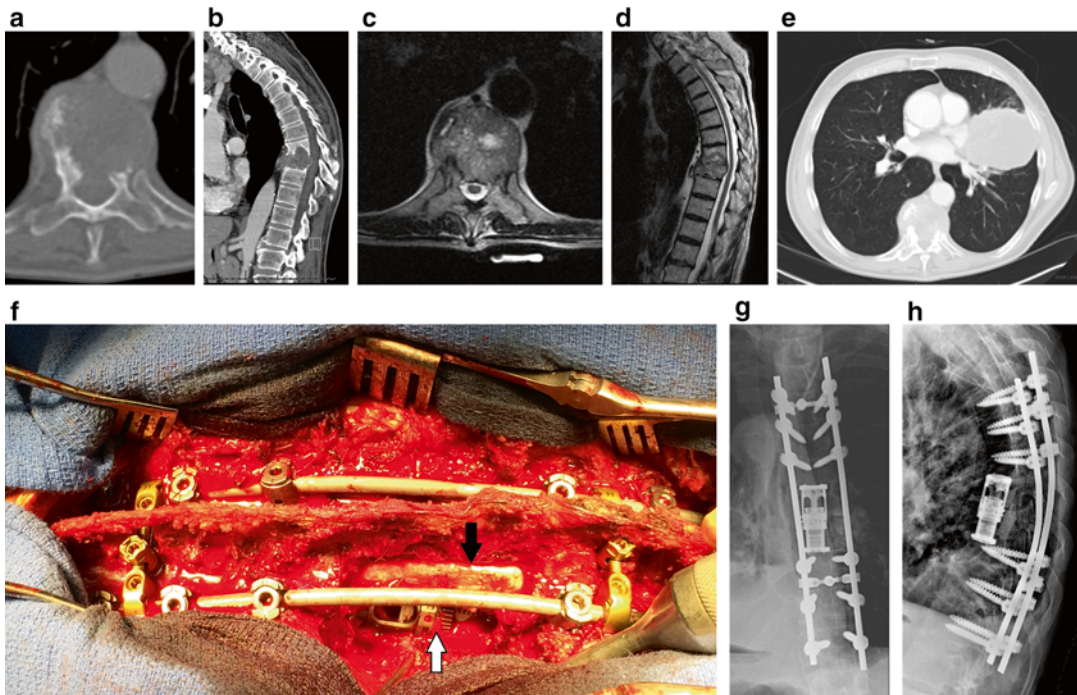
Case example with preoperative axial (a) and sagittal (b) CT scan imaging showing nearly complete replacement of the T9 vertebral body by non-small-cell lung carcinoma, along with partial cavitory destruction of T8. In addition, corresponding axial (c) and sagittal (d) T2-weighted MRI imaging showing thecal sac compression without spinal cord deformation (SOSG 1b). CT scan
